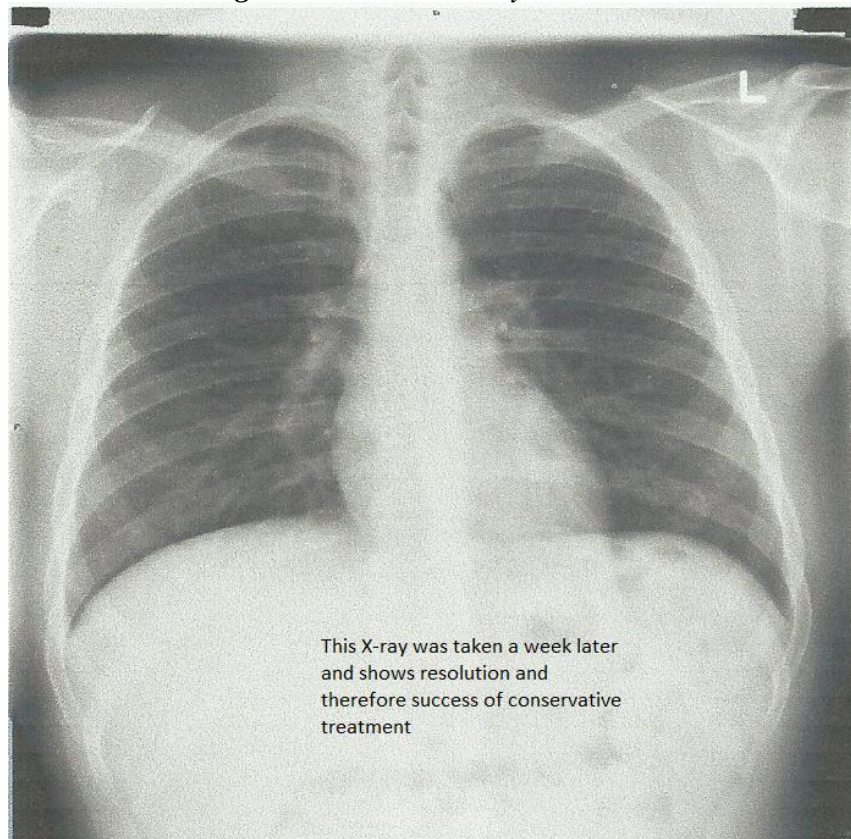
Normal X-Ray, PA
